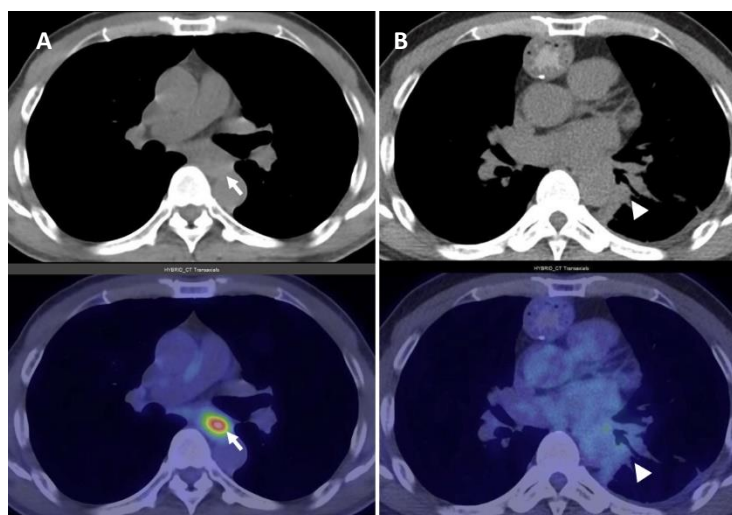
(A) Axial ¹⁸F-FDG PET/CT images from the initial staging scan (August 2022) demonstrate ¹⁸F-FDG-avid uptake in the mid-esophagus (arrow), corresponding to the primary tumor. (B) Follow-up ¹⁸F-FDG PET/CT performed in March 2025, after the patient had undergone esophagectomy with gastric pull-up reconstruction, shows a mildly hypermetabolic lesion in the left lower bronchus (arrow head), located adjacent to the previous tumor bed, suggestive of intraoperative tumor cell seeding
